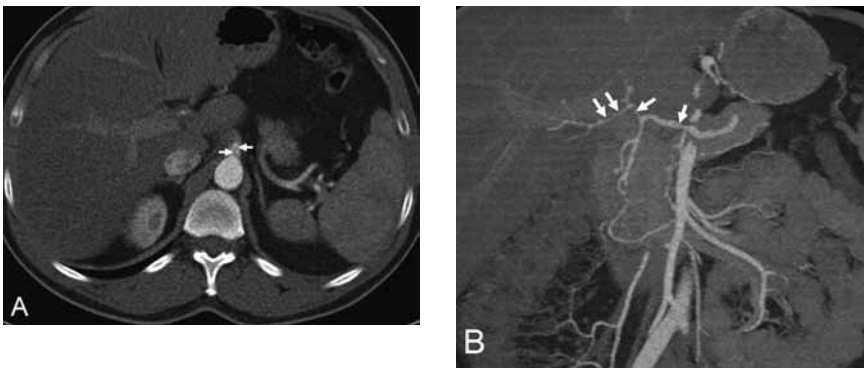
Axial CT (A) and coronal MIP images (B) show aortic dissection extending from celiac artery (arrows) to hepatic artery and of their branches (arrows).
